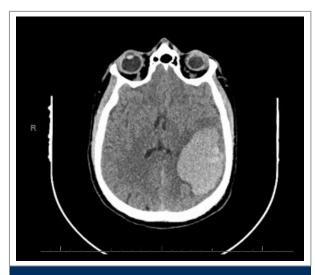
A CT brain image showing the large intracerebral haematoma.
